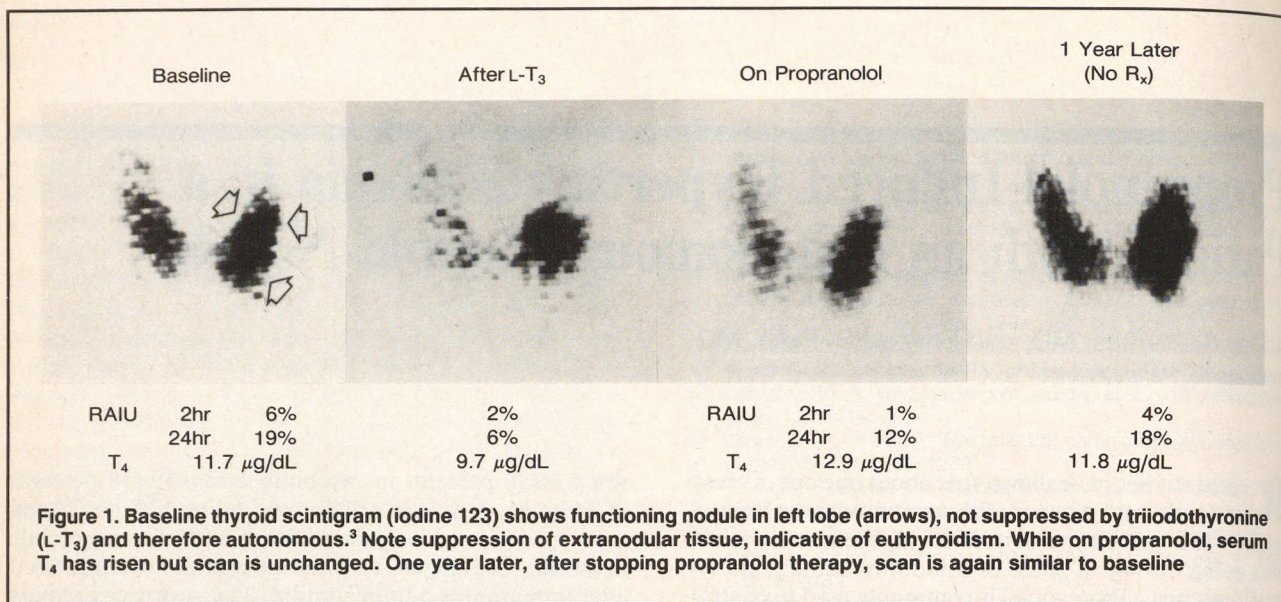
Baseline thyroid scintigram (iodine 123) shows functioning nodule in left lobe (arrows), not suppressed by triiodothyronine (L-T₃) and therefore autonomous.³ Note suppression of extranodular tissue, indicative of euthyroidism. While on propranolol, serum T₄ has risen but scan is unchanged. One year later, after stopping propranolol therapy, scan is again similar to baseline
